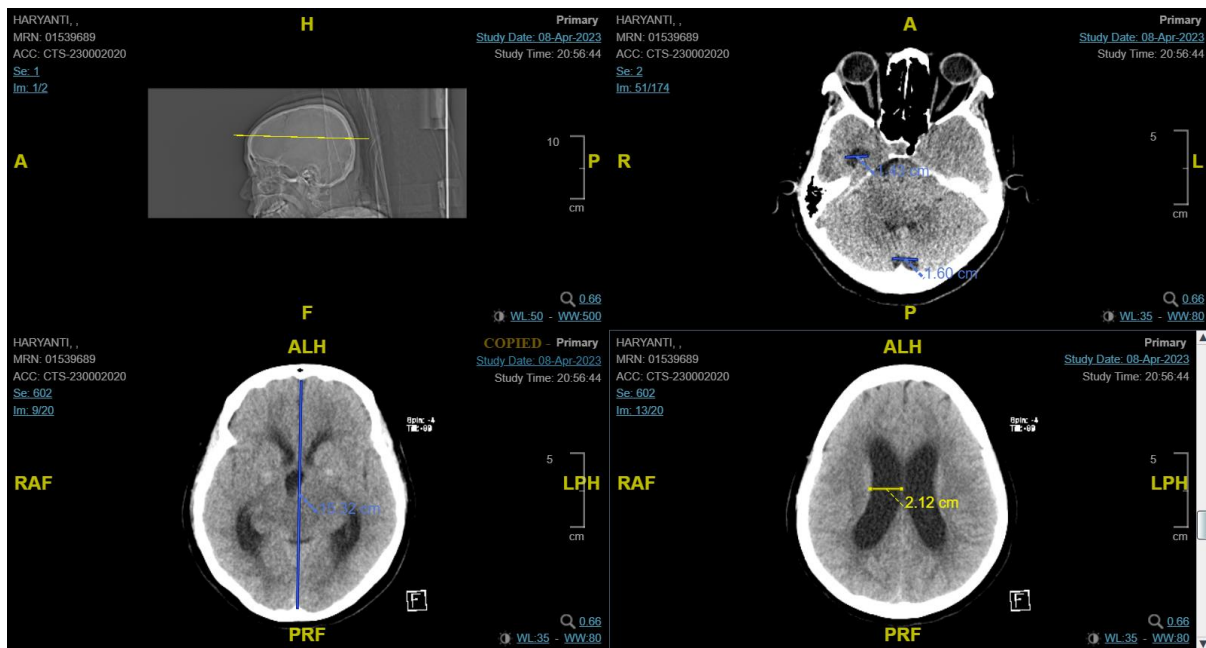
Computed tomography scan results taken on April 8th 2023.
